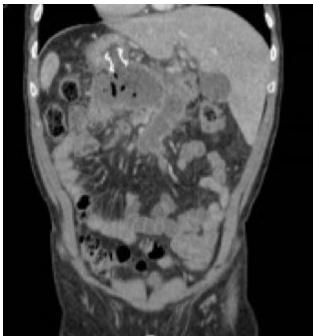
Abdominal (coronal) CT image showing a transgastrically placed LAMS positioned in WON.
